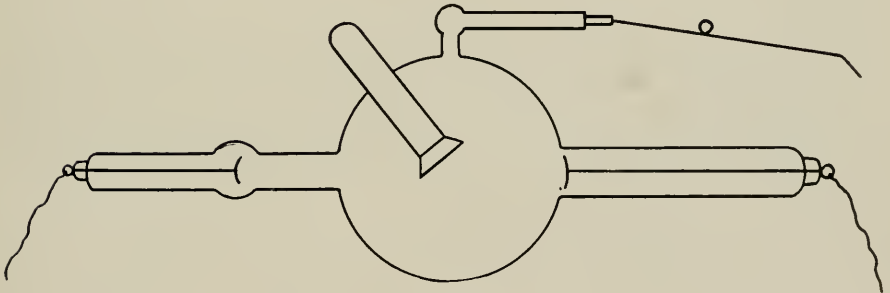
High-frequency X-ray tube.
